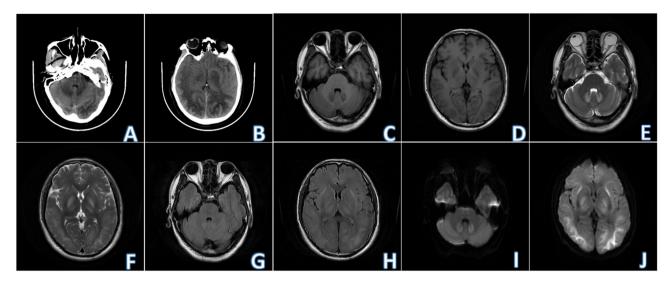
Non-contrast brain CT and MRI (2023-04). (A and B) Non-contrast brain CT showed multiple symmetrical patchy low-density shadows with unclear boundaries in bilateral basal ganglia, bilateral frontal parietal temporal occipital white matter areas and bilateral cerebellar dentate nuclei. (C-J) Non-contrast brain MRI revealed multiple symmetrical patchy T1WI hypo-intensity; T2WI hyper-intensity; T2-FLAIR hyper-intensity; DWI hyper-intensity with blurred edges in the bilateral basal ganglia (outer capsule and globus pallidus), thalamus, frontal parietal temporal occipital white matter area and bilateral cerebellar dentate nucleus. CT, computer tomography; MRI, magnetic resonance imaging; T1WI, T1-weighted imaging; DWI, diffusion-weighted imaging.
